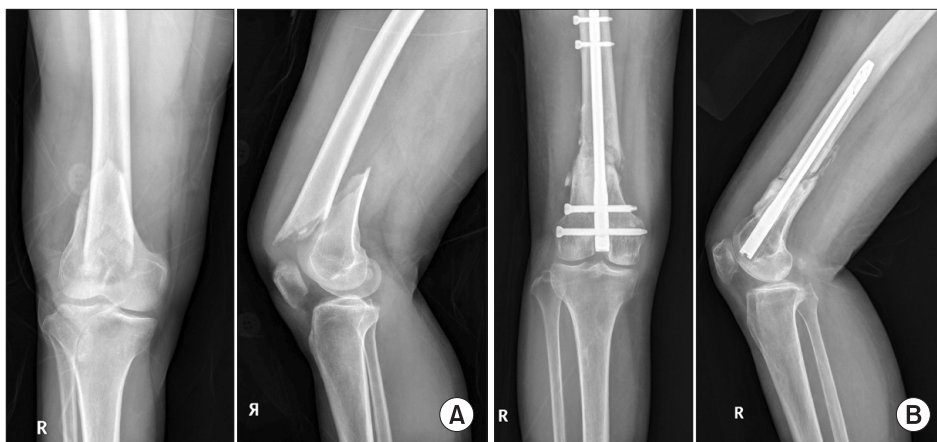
(A) Preoperative radiographs of the right knee in a 71-year-old woman. (B) Radiographs taken 1 year after surgery. We performed retrograde intramedullary nailing with cement augmentation. We achieved good mechanical stability of the bone implant construct and recommended early rehabilitation.
